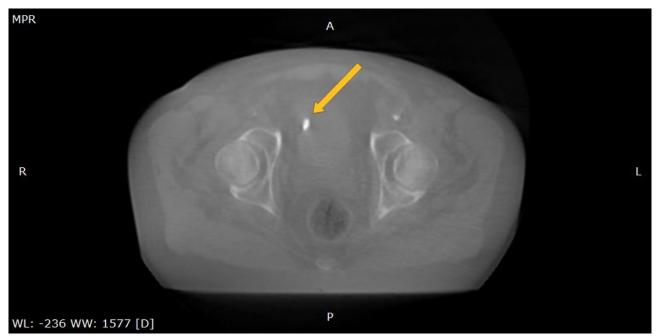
BioXmark[®] in bladder, CBCT scan
